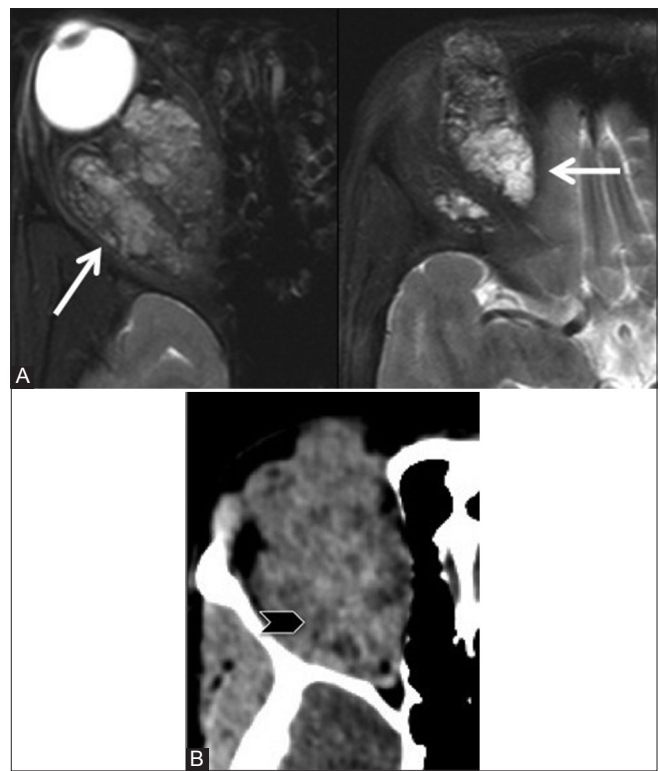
(A and B): Compressive optic neuropathy: Venolymphatic malformation. Axial T2 fat-saturated (A) images of a 12-year-old girl with proptosis and decreased right vision showing an encapsulated, diffuse multicompartmental T2-heterogeneous lesion with fluid-fluid levels (arrow) suggestive of venolymphatic malformation. On CT scan (B) the lesion shows minimal heterogeneous post-contrast enhancement (arrowhead)
